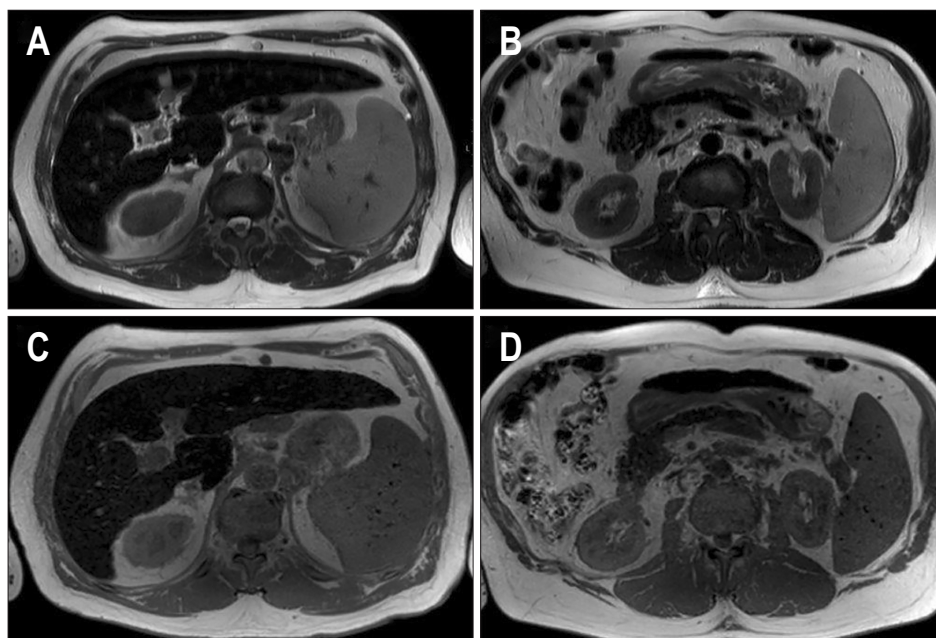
Axial T2-weighted images (A, B) and axial T1 in-phase (C, D) images of a male patient with cirrhosis, hyperferritinemia (3,000 ng/mL) and elevated transferrin saturation (80%). There is low signal intensity of the liver and pancreas related to iron deposition. Hereditary hemochromatosis (HH) was excluded on the basis of negative genetic tests. Using a multi-echo sequence (not shown), the liver $R2^*$ was 735 s^{-1} (LIC $178 \text{ } \mu\text{mol/g}$), pancreatic $R2^*$ was 400 s^{-1} and spleen $R2^*$ was 40 s^{-1} . Although liver and pancreas involvement typically accompanies HH, patients with non-HH cirrhosis can also present iron overload in other organs, such as the pancreas mimicking HH.
